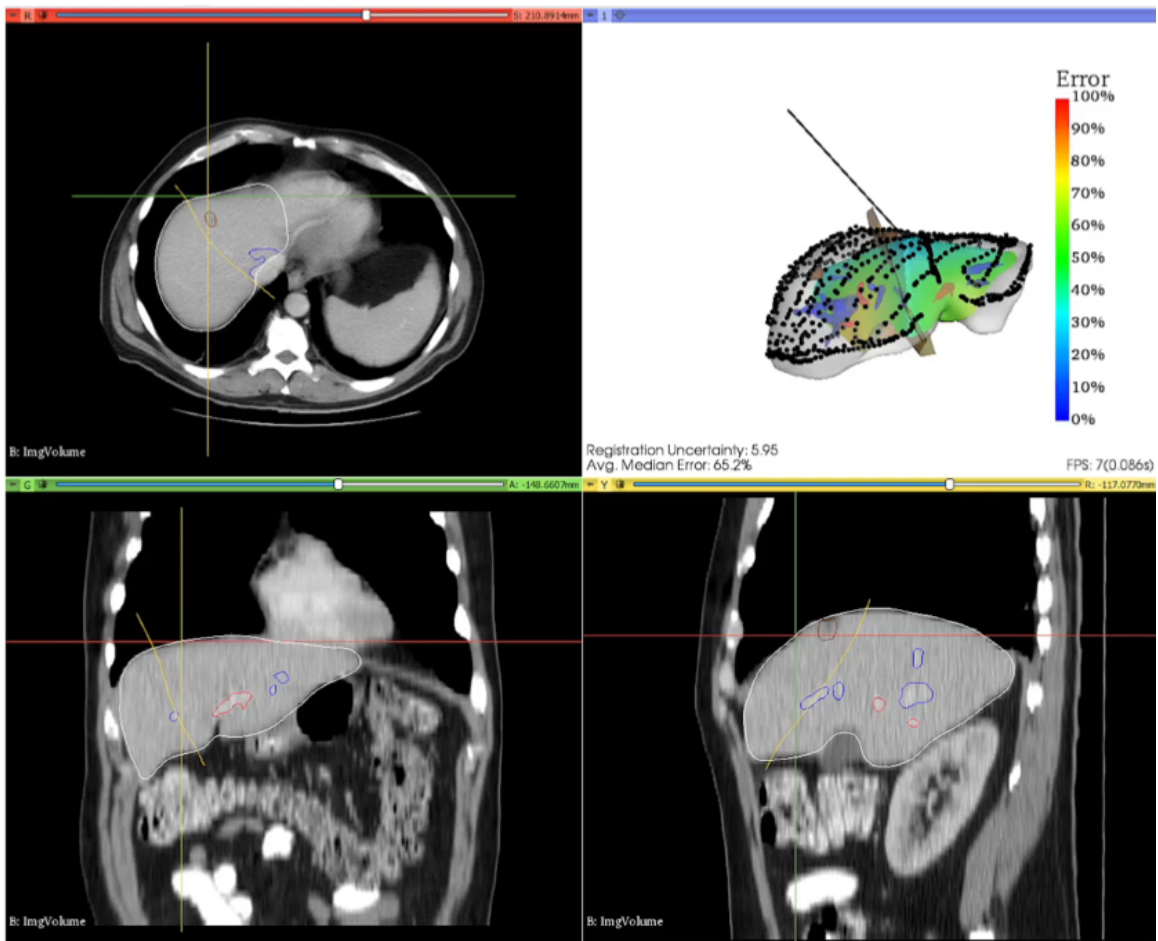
Image guidance module for liver resection, showing three cross-sections of an abdominal CT, with vessel segmentations shown in red and blue, and the planned resection plane in yellow. The stylus position is delineated with the cross hairs in the CT images, and with the black stylus model in the upper right 3D scene rendering. The 3D scene rendering shows the surface data collected with the tracked stylus, and the error estimation overlaid showing registration uncertainty.
